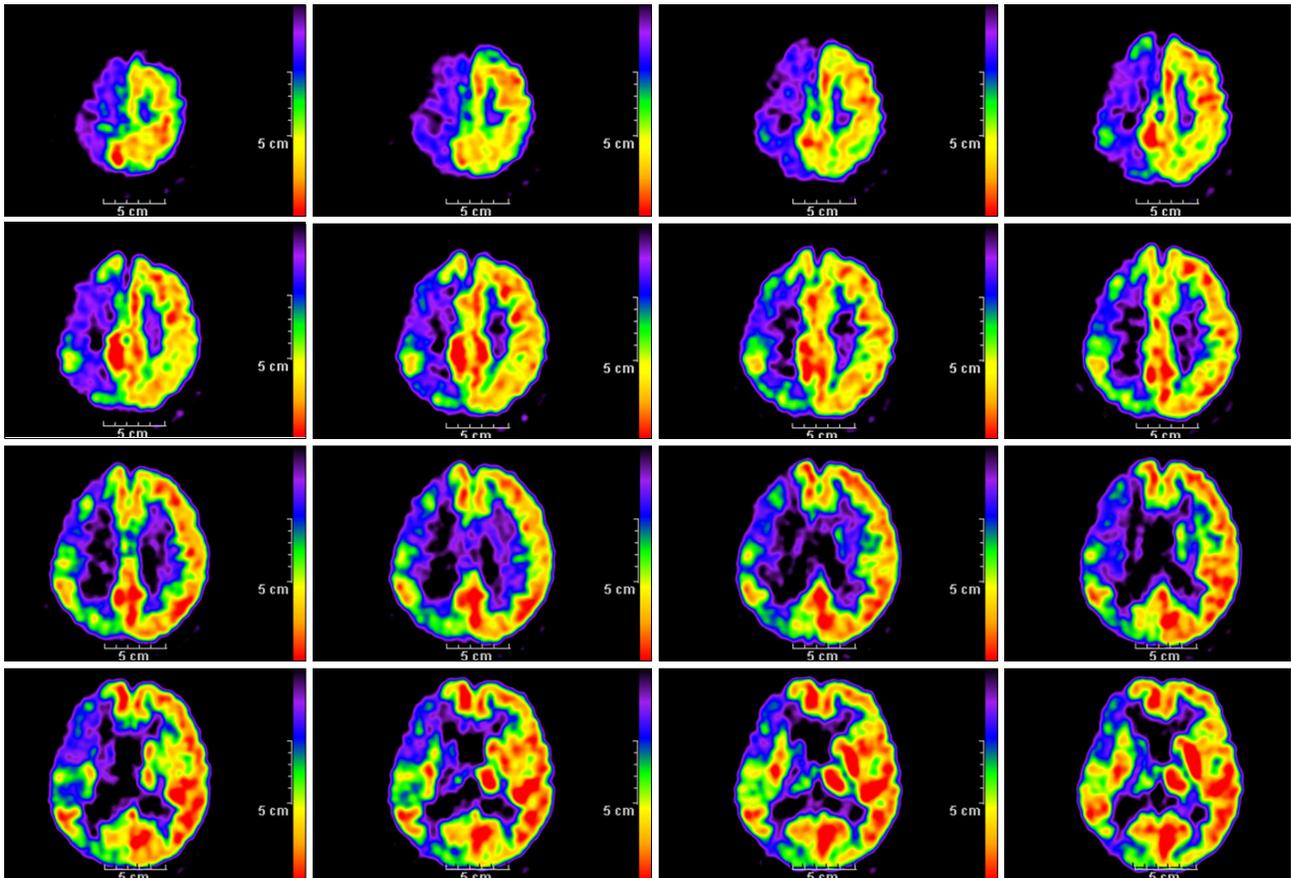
18F-FDG Brain PET showed decreased FDG uptake in entire right hemisphere, especially in right MCA territory.
